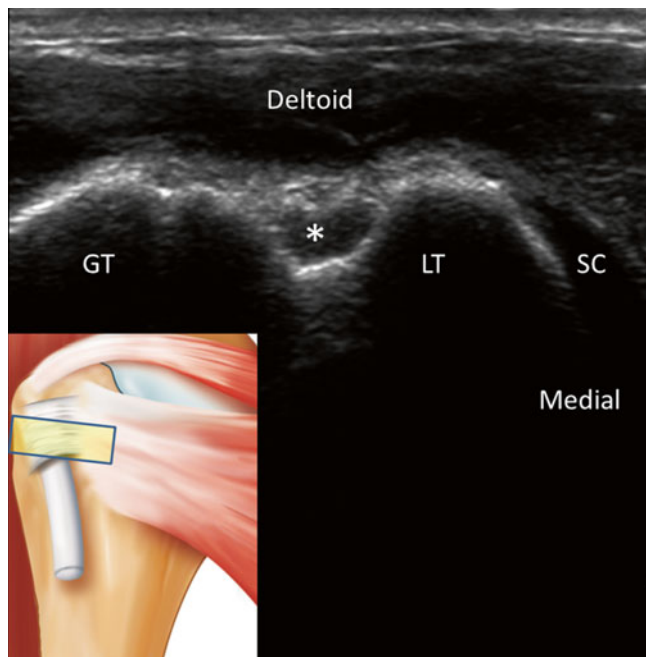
Sonogram similar to Fig. 25.2 except a different tilt of the ultrasound probe. As a result, the long head of biceps (*) look hypoechoic. *SC* subscapularis (Reproduced with permission from Philip Peng Educational Series)
